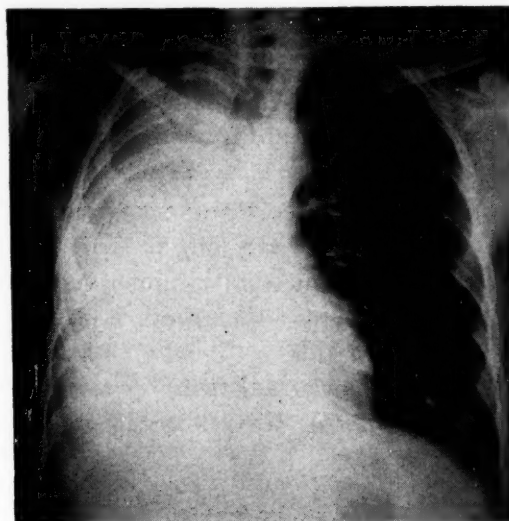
Roentgenogram of lungs one month after removal of right lung. Metastases are developing in left lung.
